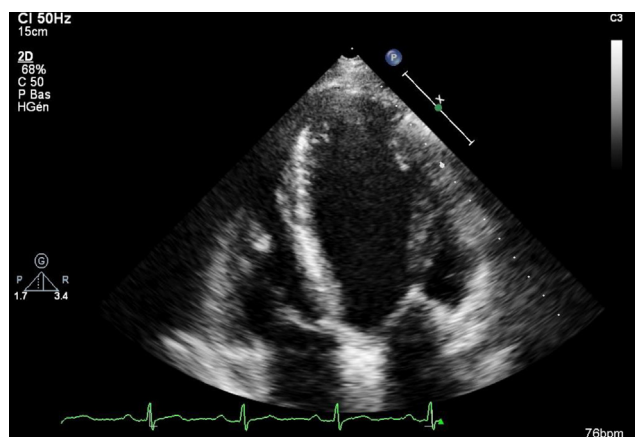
Patient with toxic aortic and mitral valvulopathy due to benfluorex. On this apical four-chamber view using two-dimensional echocardiography, the mitral leaflets have lost their flexibility. Note the marked remodelling of the mitral subvalvular apparatus, with slight thickening of both leaflets.
